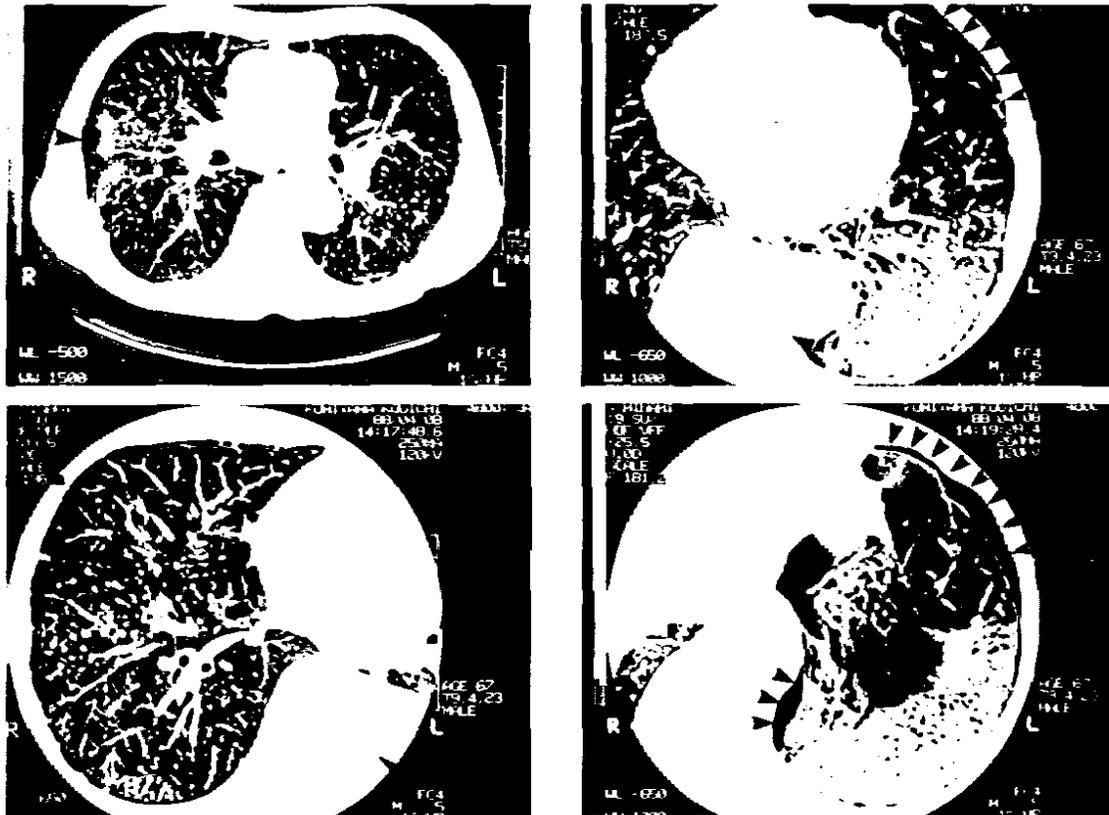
CT images demonstrate more evident pneumothorax, the collapsed lower lung and bullae. (arrow) These bullae and blebs are not visualized on the conventional chest radiograph. Dissemination of silicotic nodular high densities are also clearly visualized which are located in the middle and posterior lung regions.
